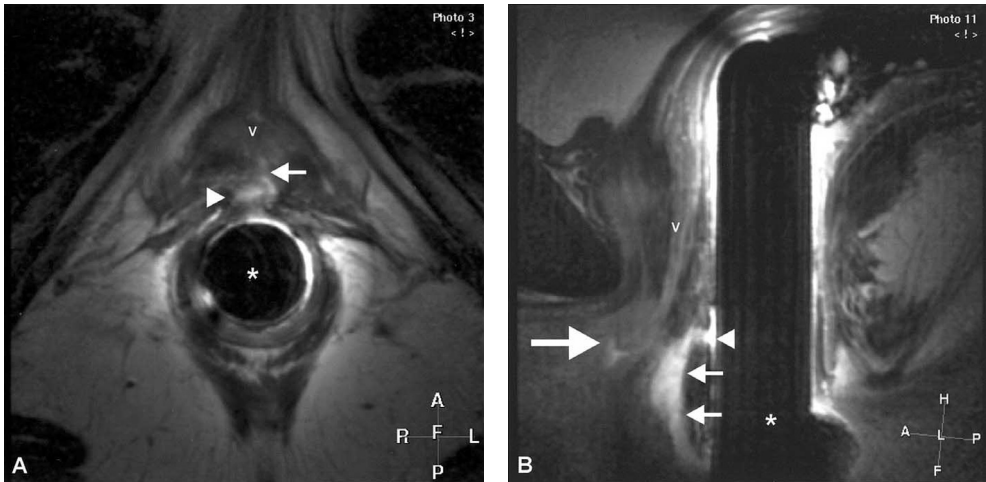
Concurrent perianal and anovaginal fistula. (A) Axial T2-weighted fast spin-echo (FSE) endoanal MR image (TR/TE = 2454/100 ms) with a perianal fistula (arrow) anteriorly extending from the anal canal to the lower part of the vagina. Local widening of the fistula tract (arrowheads) at the level of the rectovaginal septum can be seen, indicative of a small abscess. V, vagina; endoanal coil (*). (B) On the mid sagittal T2-weighted FSE image (TR/TE = 2443/100 ms), the anovaginal fistula track is demonstrated with the internal opening in the anal canal (arrowhead) and the internal opening in the vagina (thick arrow). The perianal fistula track (small arrows) is also demonstrated on this slice. V, vagina; endoanal coil (*).
